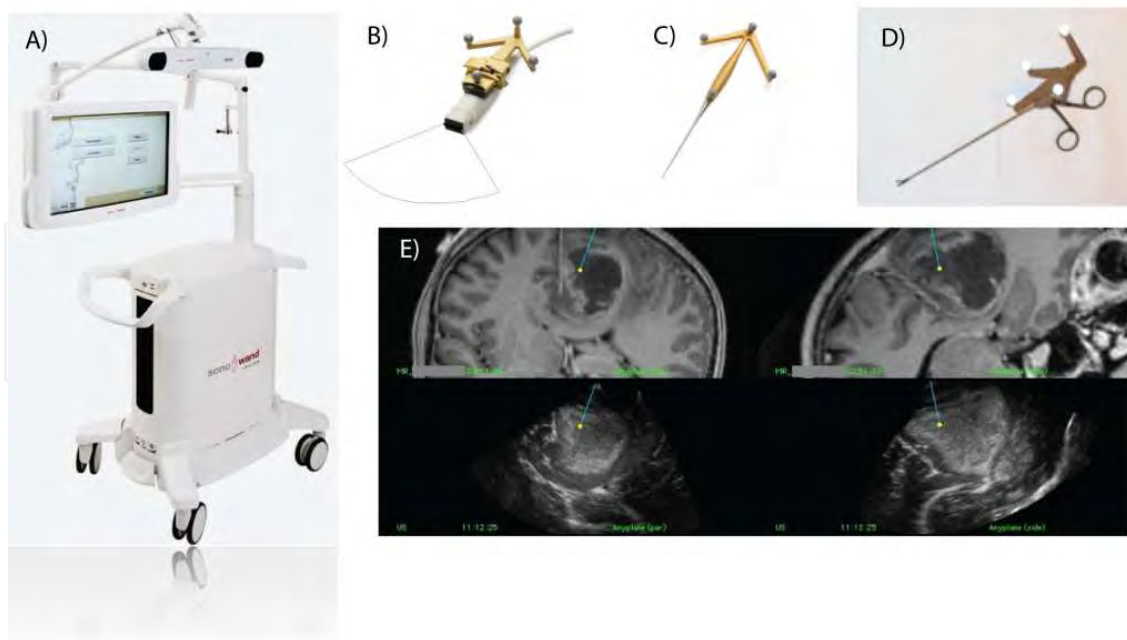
The Sonowand Invite® system for intraoperative ultrasound imaging and navigation (A), various tools of the navigation system equipped with optical localizer units showing one phased array ultrasound probe (B), a navigation pointer (C), a biopsy forceps (D), and a screen dump of the navigation display showing reformatted MR images in top row, and corresponding reformatted ultrasound images in bottom row (E). The tip of the navigated instrument is indicated with a bright spot in the reformatted image slices
